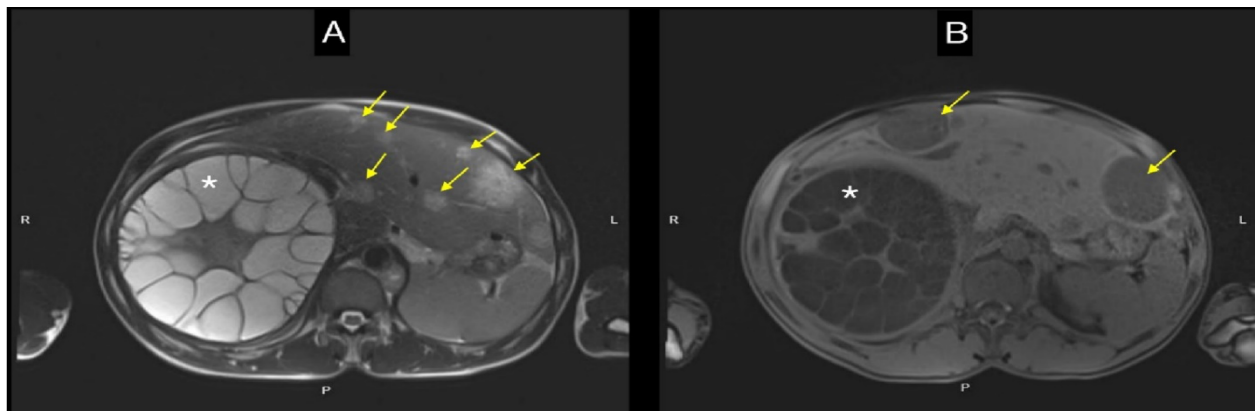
The MRI examination shows a giant septate cystic lesion with thickened walls (asterisk) and multiple contrast-enhancing lesions (arrows)
